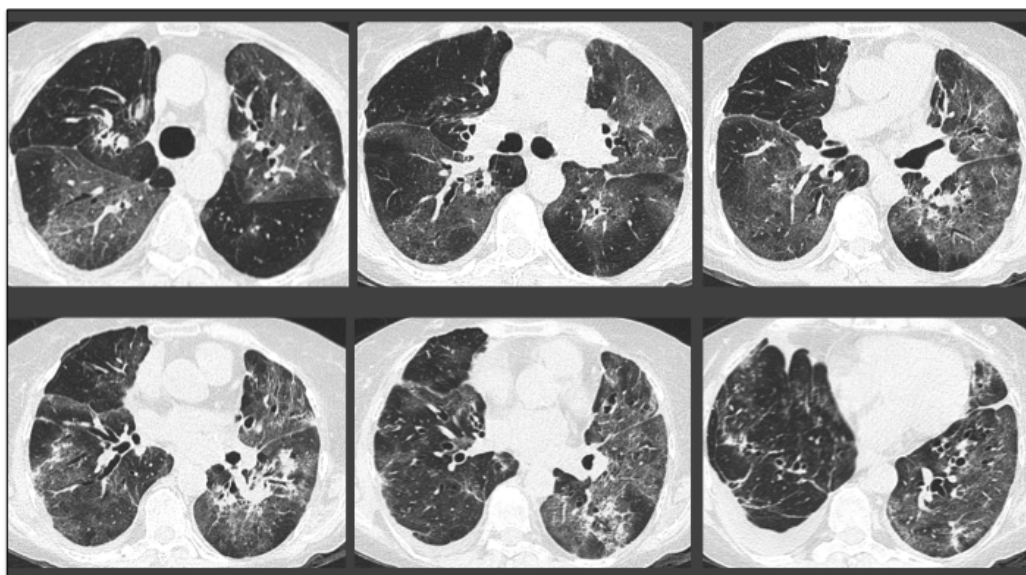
CT scan from patient 1
